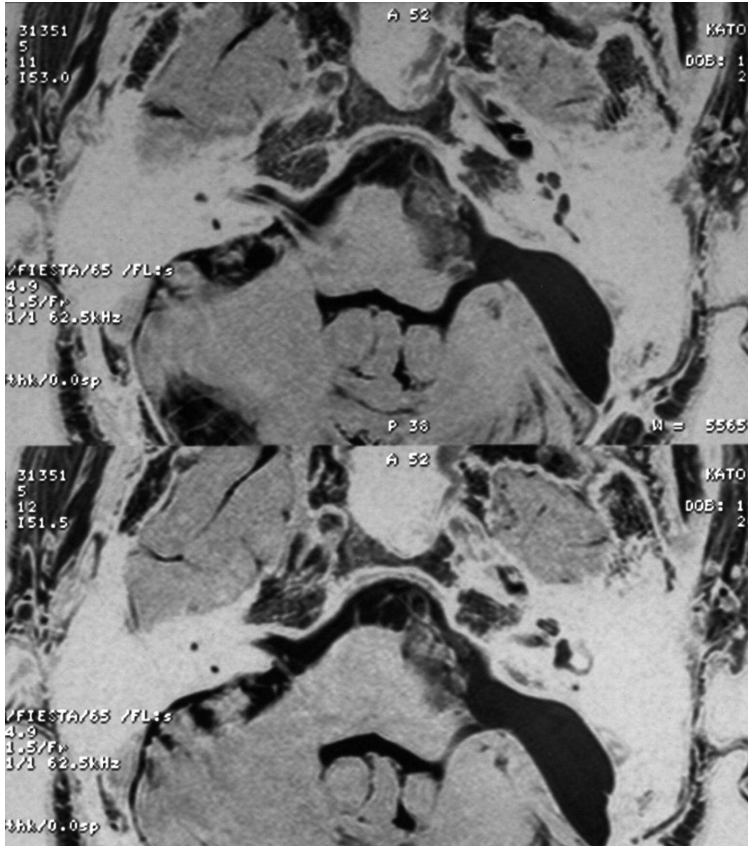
Remnants of epidermoid tumor are clearly visualized with special MRI. Sequence named FIESTA.
